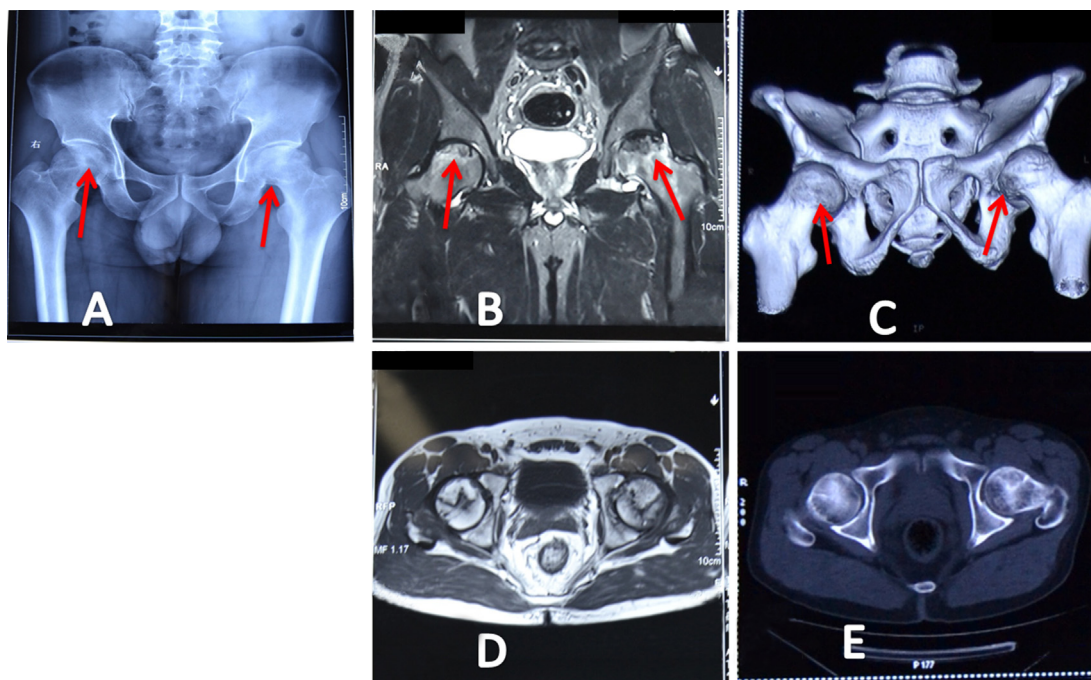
(A) Dual X-Ray absorptiometry, (B) magnetic resonance imaging, and (C) computed tomography of a 41-year-old man with bilateral osteonecrosis of the femoral head (red arrows), and showing the Ficat and Arlet Stage II and Stage III lesions in the right and left femoral heads, respectively. The volume, angle, and arc of osteonecrotic lesions are detected on (D) magnetic resonance imaging and (E) computed tomography for guiding further treatment.
